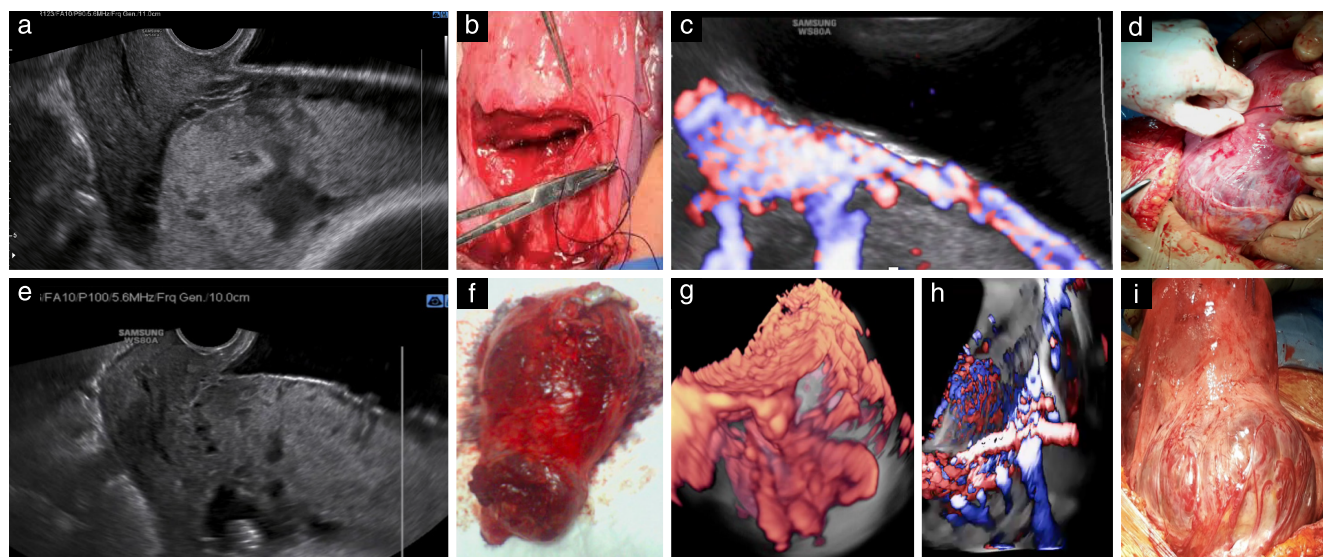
Ultrasound and surgical images in four women with placenta previa, classified prenatally using ultrasound staging system for placenta accreta spectrum (PAS) disorders. (a,b) In woman with PAS0, placenta showed lacunae but no other signs of invasion on ultrasound (a); at surgery, lower uterine segment seemed unaffected and there was no macroscopic evidence of PAS disorder (b). (c,d) In woman with PAS1, placenta showed presence of lacunae and abnormal bladder interface but no uterovesical hypervascularity on ultrasound (c); at surgery, there was placental adherence but no sign of macroscopic invasion through uterine serosa could be identified (d). (e,f) In woman with PAS2, there were signs of uterovesical hypervascularity on ultrasound (e); at surgery, there was placenta percreta invading upper and lower uterine segments but no evidence of parametrial invasion (f). (g–i) In woman with PAS3, there was increased vascularity in inferior part of lower uterine segment extending into parametrial region on ultrasound (g,h); at surgery, there was evidence of parametrial invasion (i).
